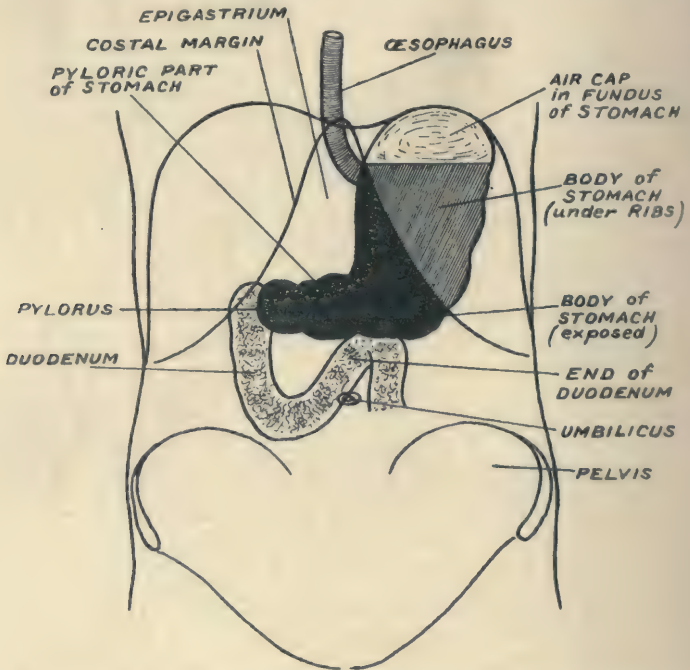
An X-ray shadow of the full stomach, with contraction waves passing towards the pylorus.
